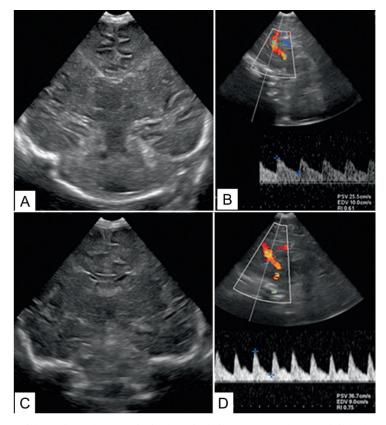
Neonate with perinatal hypoxic ischemic injury (A) and (B) Initial ultrasound study shows diffuse brain edema with increased echogenicity of the cerebral white matter, accentuated corticomedullary differentiation, and slit like ventricles. Anterior cerebral artery Doppler shows a resistive index (RI) value of 0.61. (C) and (D) Follow-up imaging after treatment, shows normalization of the B-mode imaging findings and a normal RI value of 0.75.
